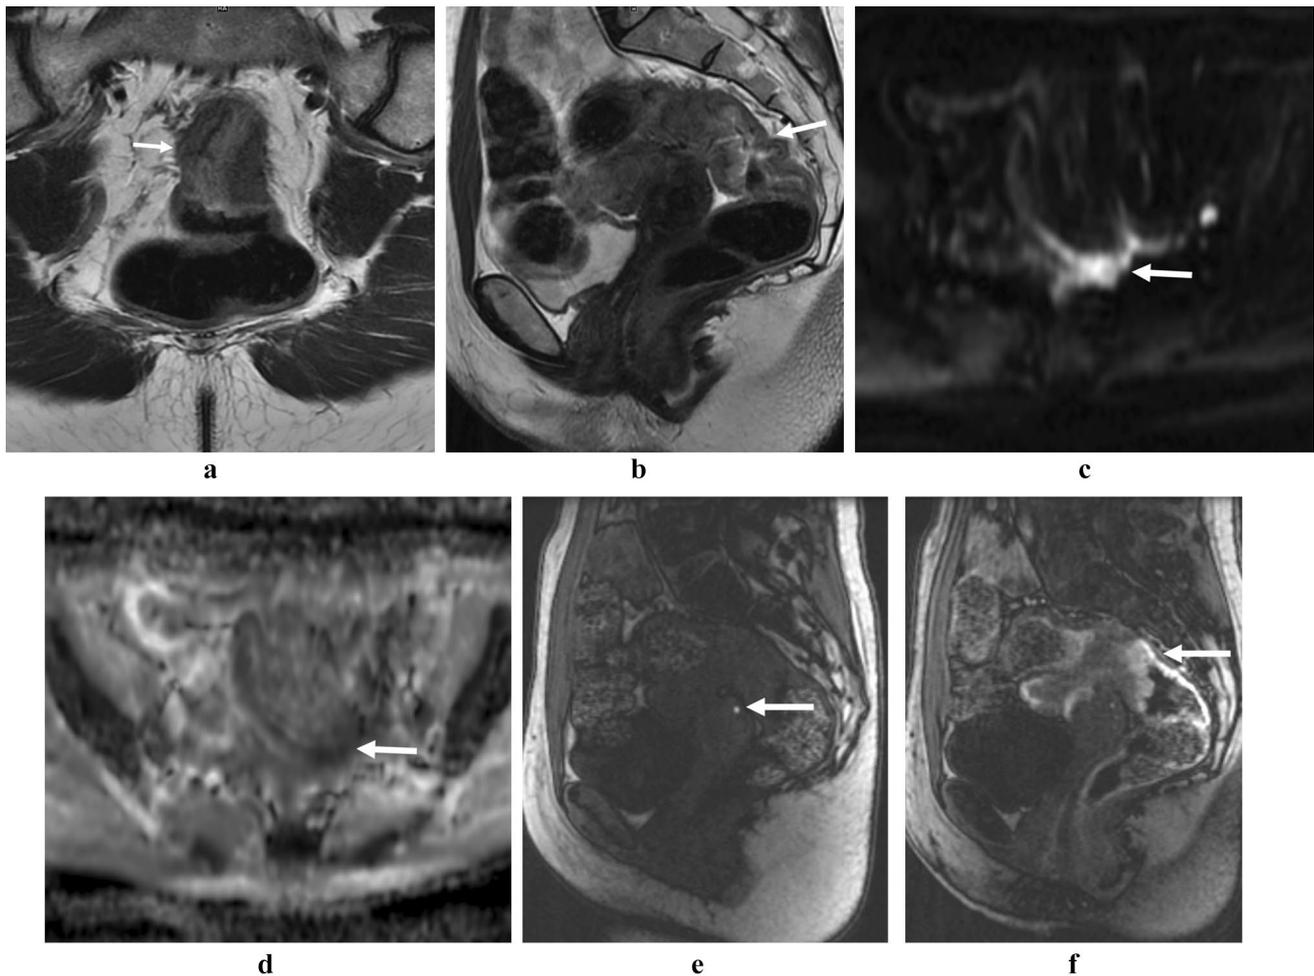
Deep pelvic endometriosis mimicking a rectal mass. Axial (a) and sagittal (b) T2-weighted images show intermediate signal rectal thickening (arrows), with areas of corresponding restricted diffusion in the deep pelvis (c and d, arrows). Pre-contrast T1-weighted
